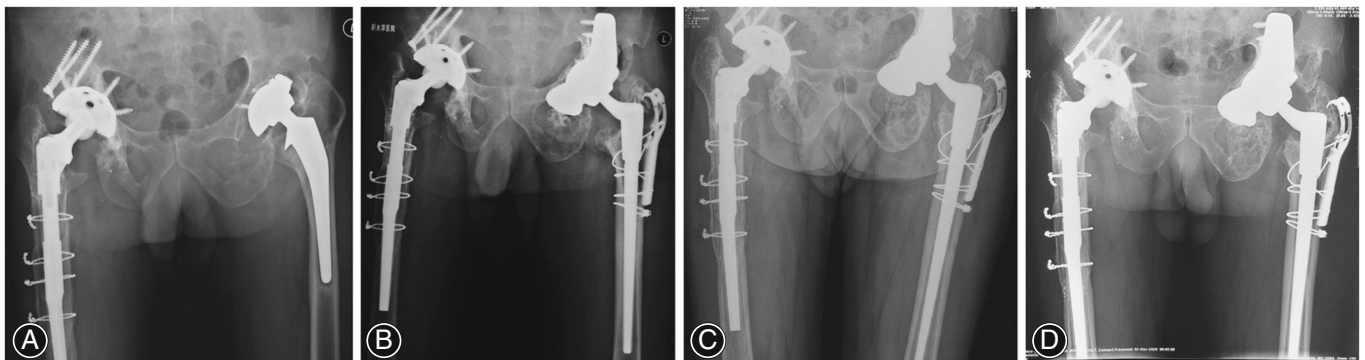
A representative case of extended ischiopubic fixation using a TM wedge augment. (A) Preoperative anteroposterior radiograph of the bilateral hips of a 60-year-old male demonstrating loosening of the left cup and substantial left ischial osteolysis. (B) Immediate postoperative anteroposterior radiograph of the bilateral hip demonstrating a wedge augment secured into the ischium to reconstruct an ischial supportive point and a TM buttress augment secured in the ilium to simultaneously reconstruct a firm superior supportive point. (C) Postoperative anteroposterior radiograph of the bilateral hips with 2-year follow-up demonstrating a stable construct on the left side with no radiolucent lines around the cup and augments. (D) Postoperative anteroposterior radiograph of the bilateral hips with 4.2-year follow-up demonstrating a stable construct on the left side with no radiolucent lines around the cup and augments
